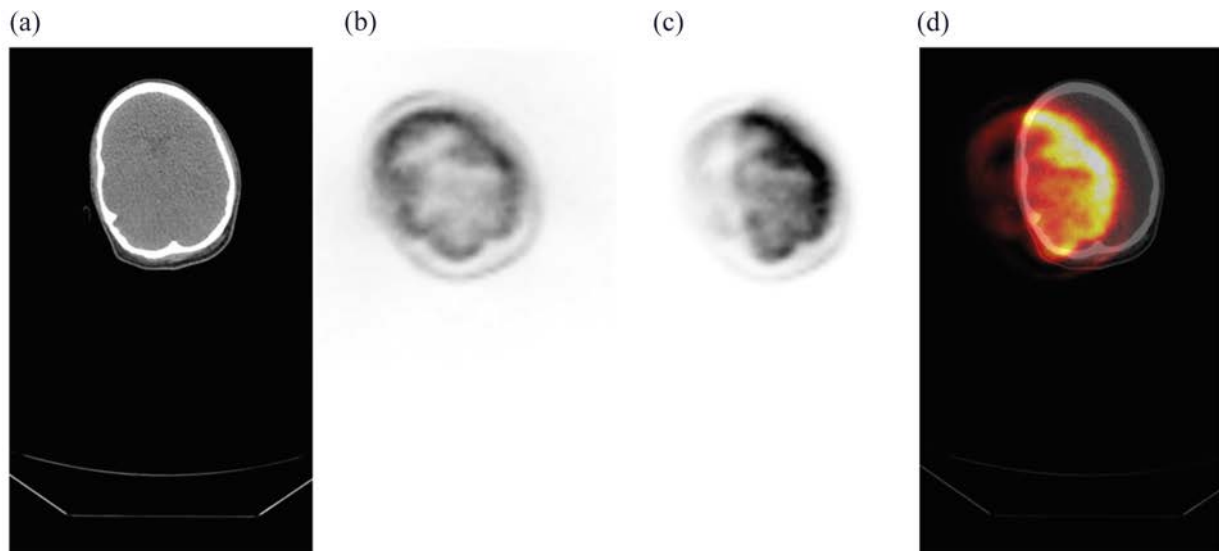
Transaxial image planes of CT (a), noAC-PET (b), AC-PET (c) and fused AC-PET/CT (d) demonstrating local PET-CT misalignment of the head resulting in a biased cortical activity. AC: attenuation corrected; noAC: not attenuation corrected.
